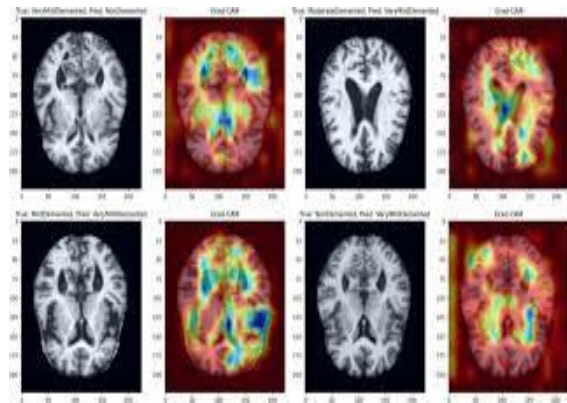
2 Proposed Output of Alzheimer's Disease from MRI Scans
